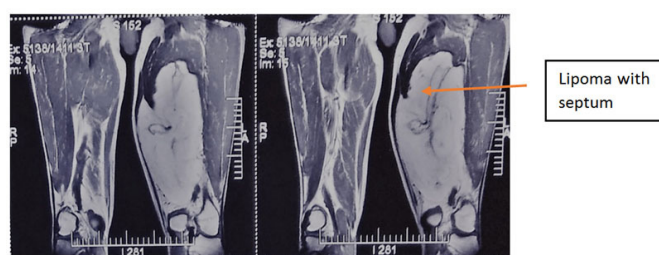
MRI showing giant lipoma.
